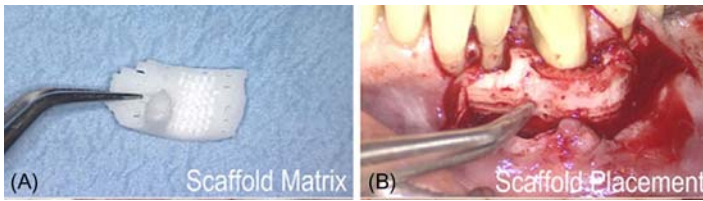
(A) Customized scaffold was 3D printed using medical-grade PCL to fit the periosteous defect using a prototyped model of the defect from the patient's cone beam computed tomography scan. (B) Placement of the 3D-printed scaffold into ridge defect following full-thickness flap exposure.
